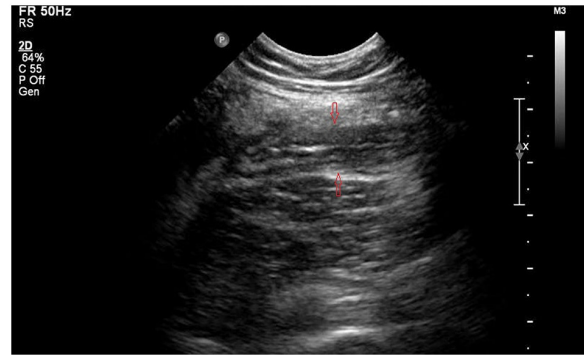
Abdominal ultrasound showing acutely inflamed appendix, as indicated by the arrows.
